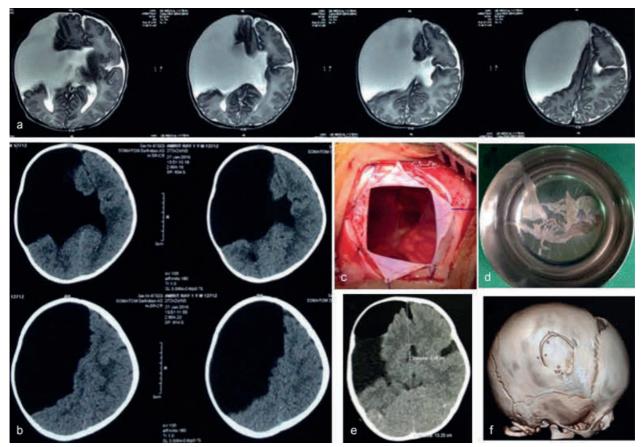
(a) MRI of the brain and (b) CT of the head showing giant right frontotemporoparietal cyst with midline shift. (c) Intraoperative photograph is showing giant cyst with clear fluid and (d) excised cyst wall. (e) Postoperative CT of the head showing adequate cyst decompression with reduced midline shift and (f) right parietal bone flap. CT, computed tomography; MRI, magnetic resonance imaging.
